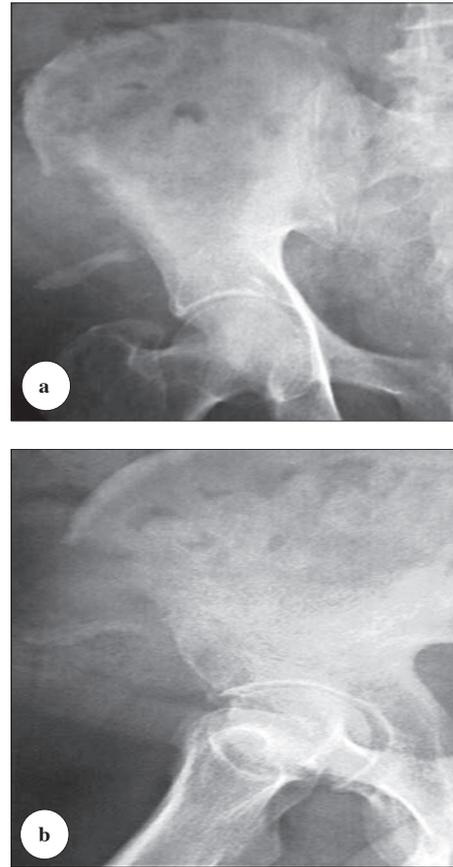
X-ray results of patient's 2 a) Anteroposterior radiograph of the right hip and pelvis showing displaced fracture of the anterior superior iliac spine after graft harvest. b) Lateral radiograph of the right hip showing displaced fracture of the anterior superior iliac spine after graft harvest.
